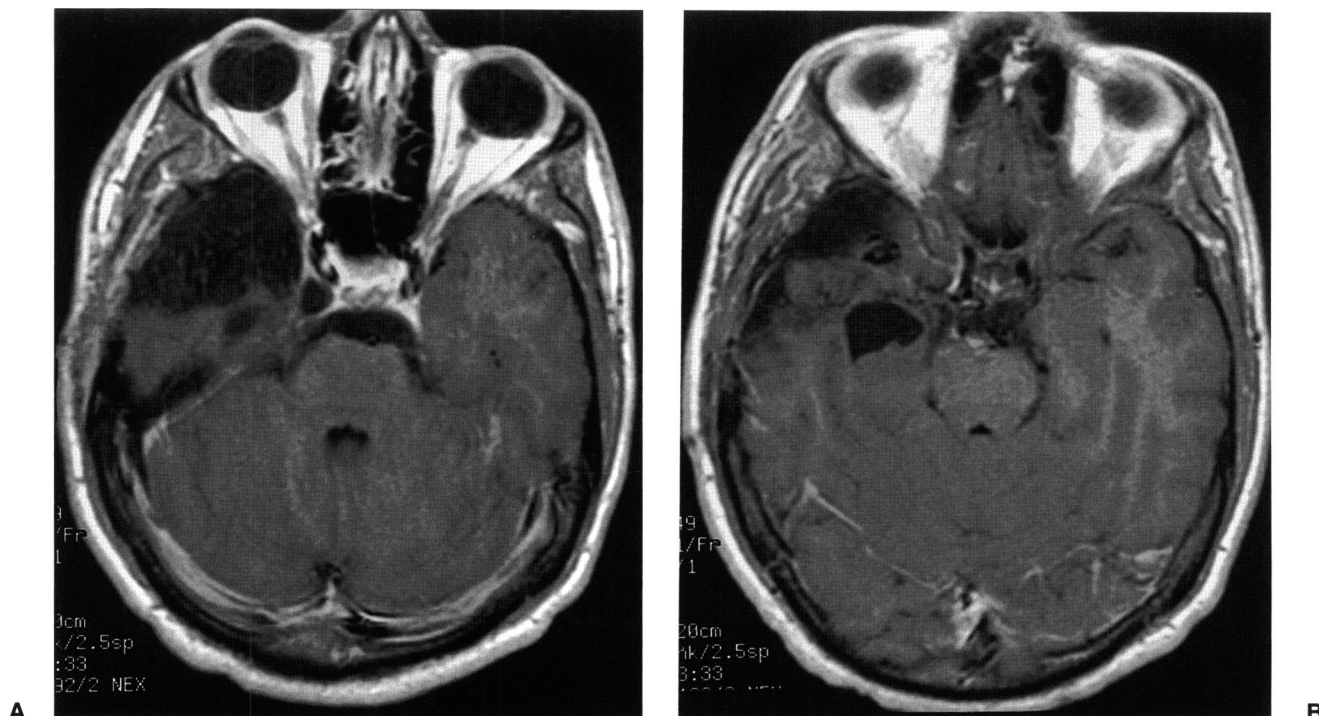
Magnetic resonance imaging scan with gadolinium in November 1992 (3½ years after the resection). A: Area of hypointensity without enhancement in the right parasellar region. B: Area of hypointensity without enhancement in the right medial temporal lobe consistent with encephalomalacia and no evidence of residual tumor.
